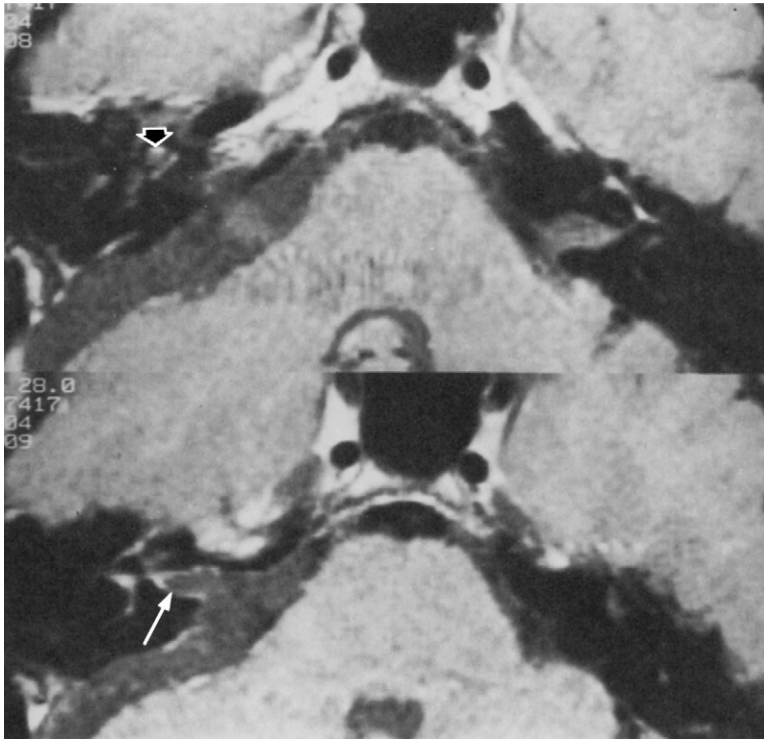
Postresection postgadolinium T₁-weighted magnetic resonance imaging scan shows enhancement along the wall of the internal auditory canal (*arrow*) with some increased signal in the cochlea (*open arrow*). The increased signal in the cochlea could be a small amount of blood. This increased signal represented a change from the preoperative examination.
